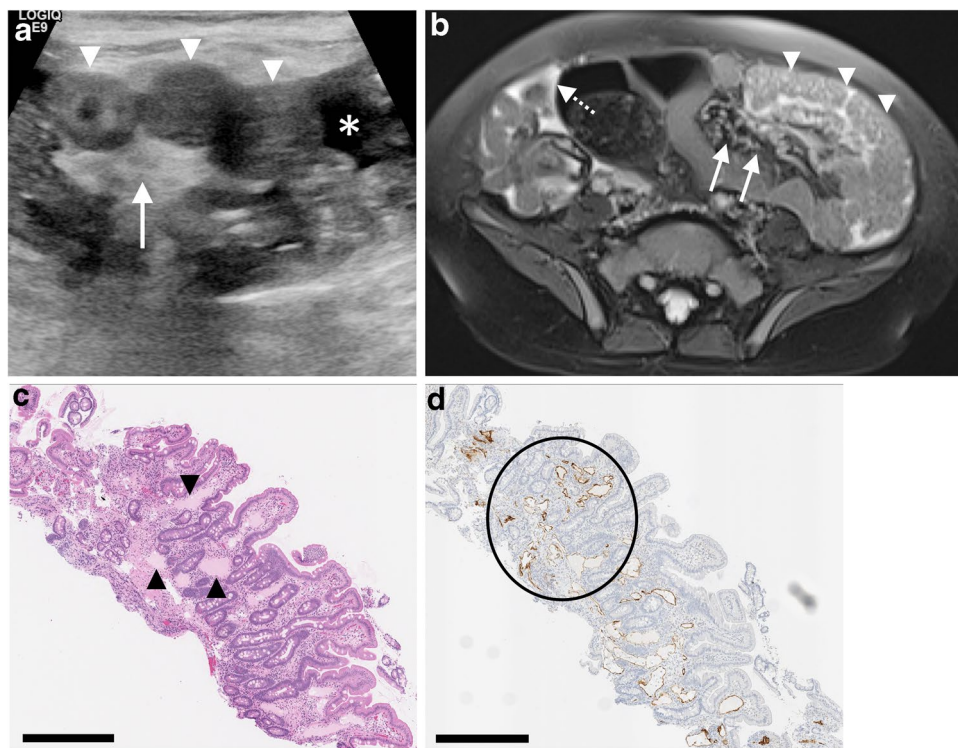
Noonan syndrome and diffuse lymphangiectasia (pulmonary and intestinal) in a 3-year-old boy. a Transverse gray-scale US image of the lower abdomen shows nonspecific mural thickening of small bowel loops (*arrowheads*) with adjacent mesenteric edema (*arrow*) and simple free fluid (*asterisk*). b Axial fat-suppressed T2-W MR image reveals nodular small bowel thickening with obscuration of the normal fold pattern and suggestion of tiny stippled cystic spaces (*arrowheads*).
